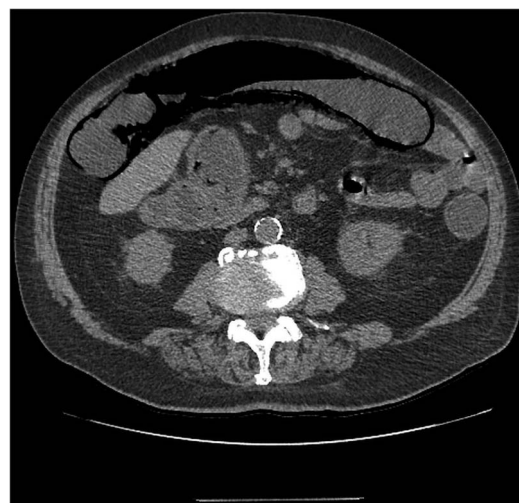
Axial plane CT scan of the abdomen showing pneumatosis intestinalis.
